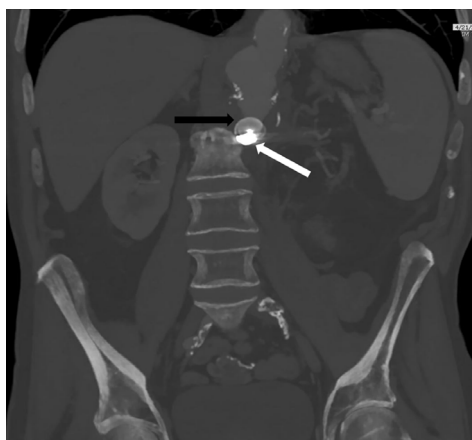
Five weeks post-operatively, the patient remained bleed-free without leukocytosis or fever. Computed tomography angiogram demonstrated improvement in peri-aortic inflammation and stable positioning of the intraluminal vascular plug (black arrow) and the microcoils (white arrow)
